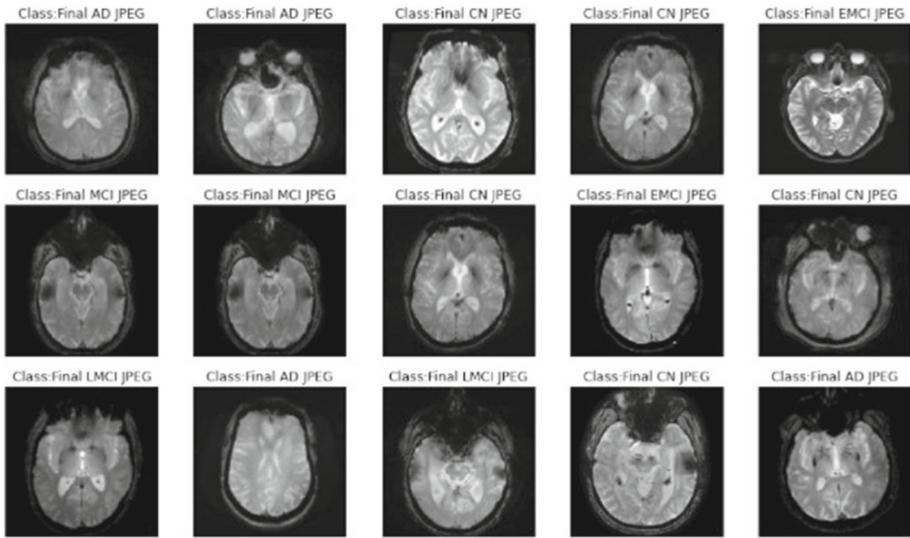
MRI Images of the 5 stages
